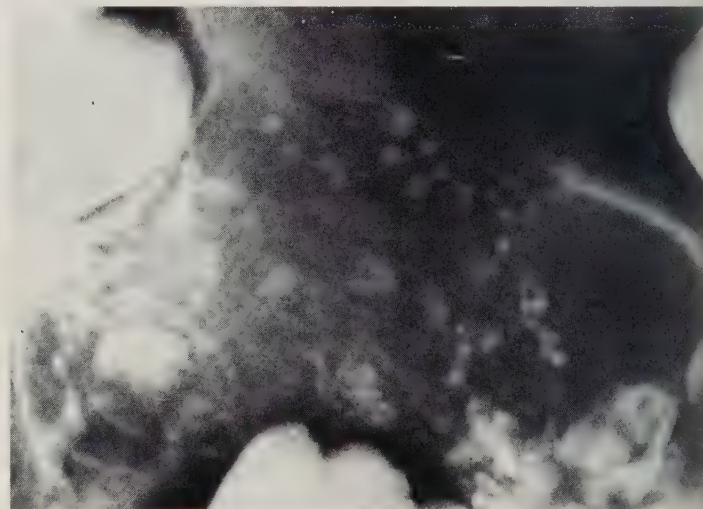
Intra-oral x-ray of lesion in the right mandible.
